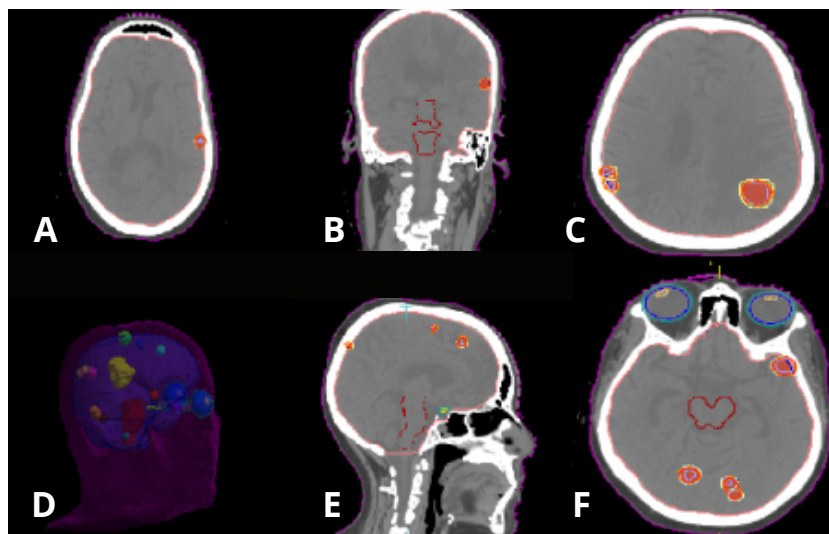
Stereotactic radiosurgery (SRS) planning. A: Coronal CT scan with a lesion in the left cerebral hemisphere. B: Coronal CT scan with lesions in the right and left cerebral hemispheres. C: Coronal CT scan with lesions in cerebral hemispheres. D: Three-dimensional planning based on CT scan. E: Sagittal CT scan with lesions in a cerebral hemisphere. F: Coronal CT scan at the midbrain level with lesions in cerebral hemispheres.
